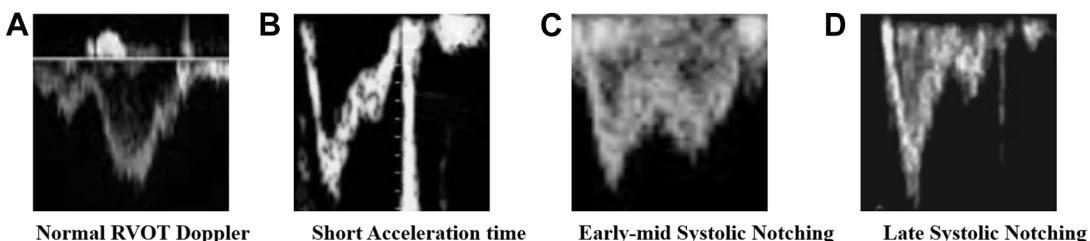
RVOT doppler patterns.
